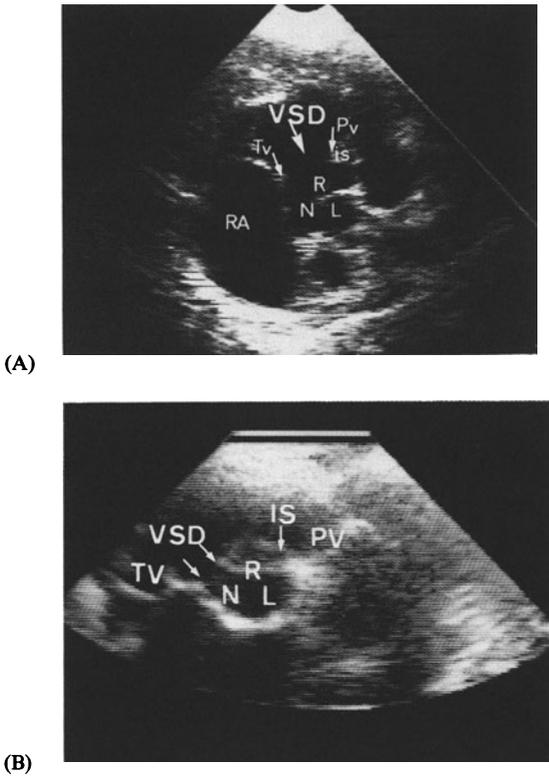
Parasternal short-axis aortic view. (A) Subaortic VSD extending to the infundibular septum (*IS*). (B) Superior extension of subtricuspid VSD. It lies beneath the commissure between the right (*R*) and noncoronary cusps (*N*) (*L*, left coronary cusp).
